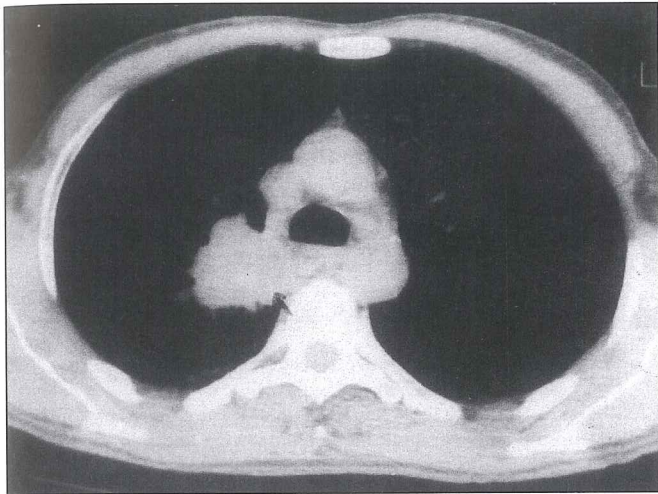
Computed tomography showing mass involving right upper lobe and lateral tracheal wall.
